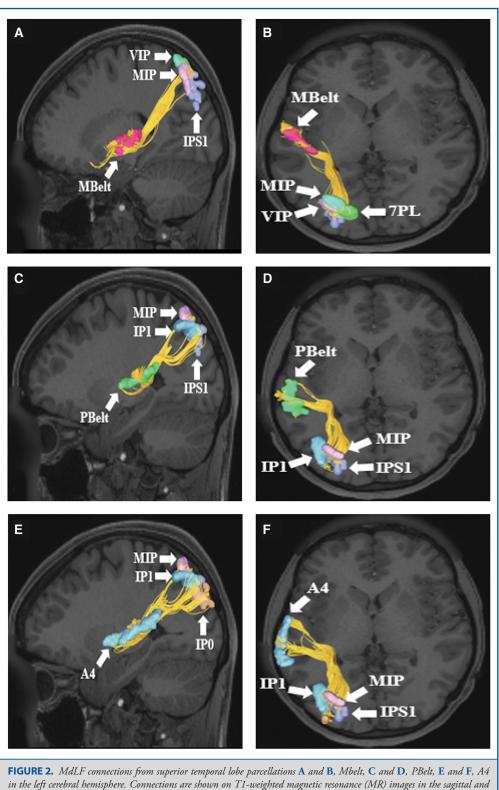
MdLF connections from superior temporal lobe parcellations A and B, Mbelt, C and D, PBelt, E and F, A4 in the left cerebral hemisphere. Connections are shown on T1-weighted magnetic resonance (MR) images in the sagittal and axial planes. All three cortical areas demonstrate structural connections to different parietal lobe parcellations, including IPO, IP1, MIP, VIP, IPS1, and 7PL. The MdLF is readily seen in this figure coursing from the superior temporal lobe posteriorly and superiorly to terminate in the parietal lobe.
